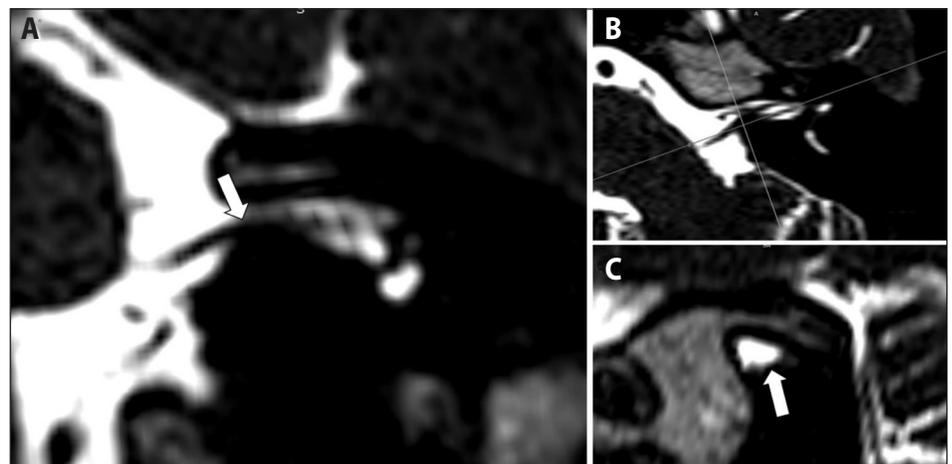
Hi-resolution T2-weighted sequence (T2-DRIVE) images reconstructed in non-orthogonal planes aligned with the orientation and direction of the 8th cranial nerve (2B); showing the protrusion causing upward compression and distortion of the cranial nerve (2A, white arrow). The nerve could not be clearly delineated from the protrusion in the cross-sectional view of the internal auditory canal (2C, white arrow)
